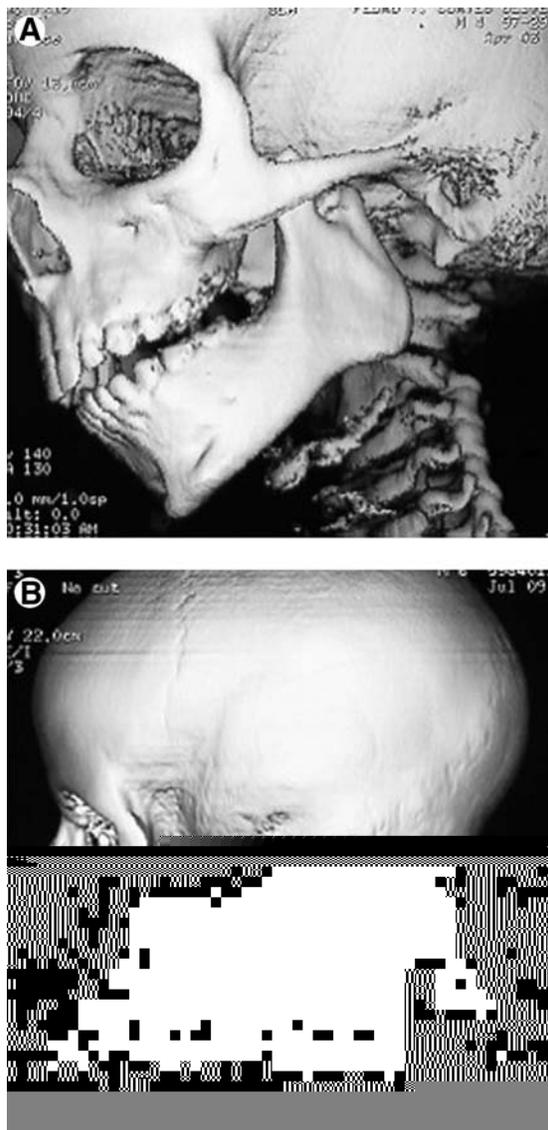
(A) Preoperative 3D CT reconstruction of the craniofacial skeleton in both patients diagnosed with CFM (Type IIA) show a deficient mandibular ramus and condyle on the affected side. (B) The postoperative reconstruction shows new bone formation in the area of the mandibular ramus.
